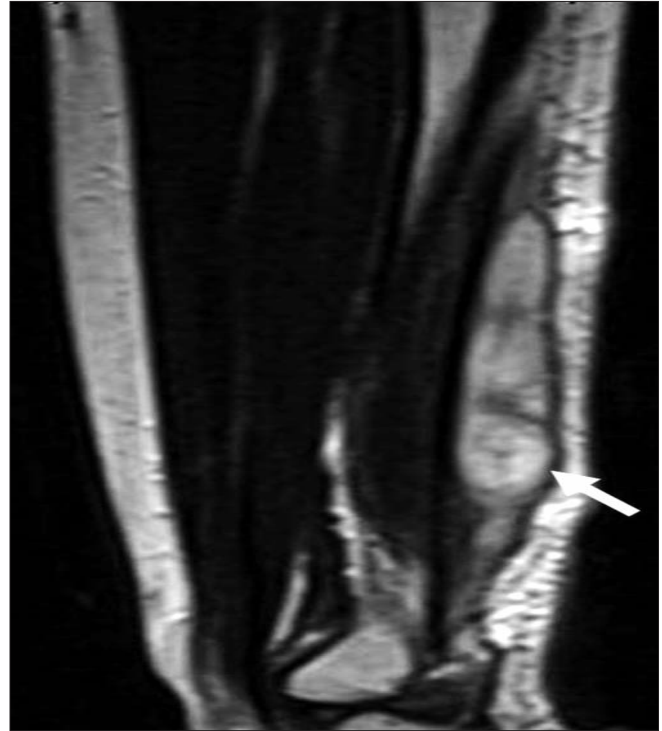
MRI of the right forearm. T2-TSE sagittal sequence shows well defined, inhomogeneous hyperintense mass in the posterior compartment, deep to the antebrachial fascia, along the extensor tendon (→), corresponding to an abscess
